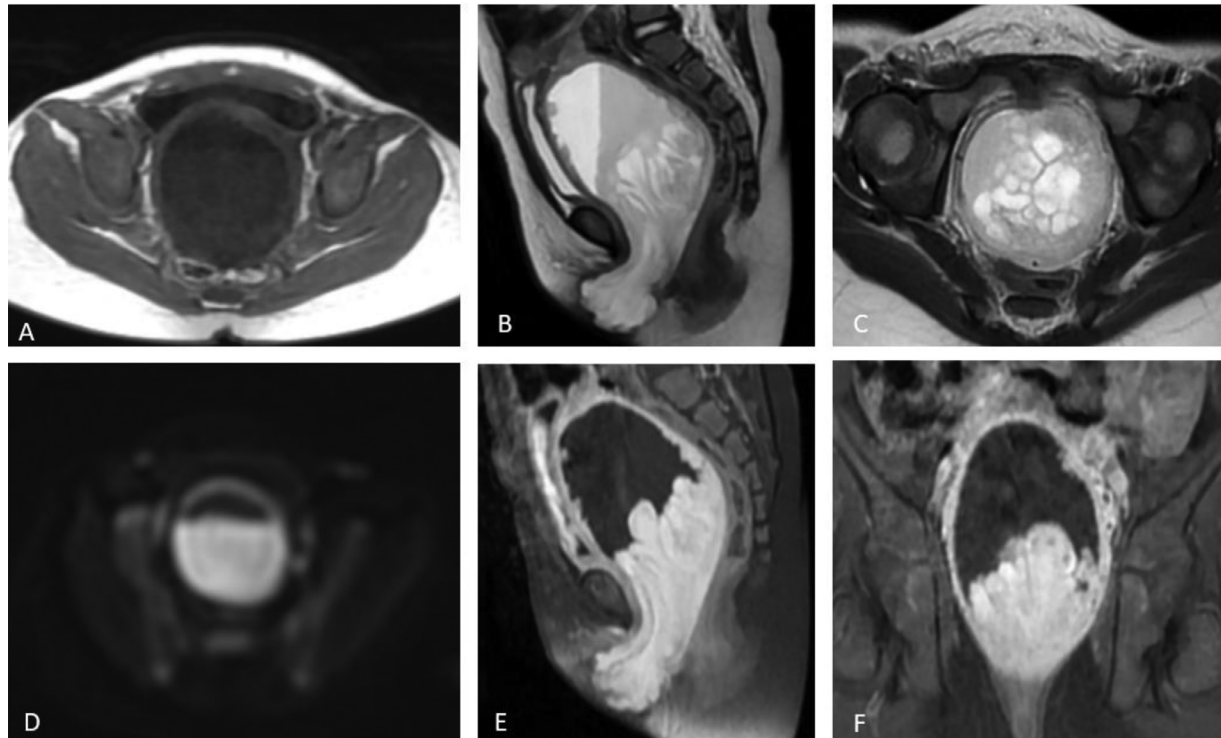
Pelvic MRI revealed a large polypoid mass occupying the vaginal lumen and extending into the vulvar region. It appeared hypointense on T1-weighted sequences (A) and heterogeneously hyperintense on T2-weighted images (B and C). The mass also showed restricted diffusion (D) and significant enhancement after gadolinium administration (E and F).
